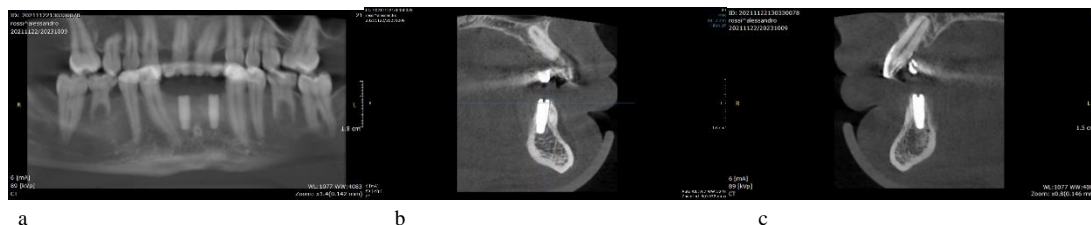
A): CBCT, frontal view: implants inserted in the regenerated site; B), C): CBCT sagittal view: clear increase in bone thickness.
